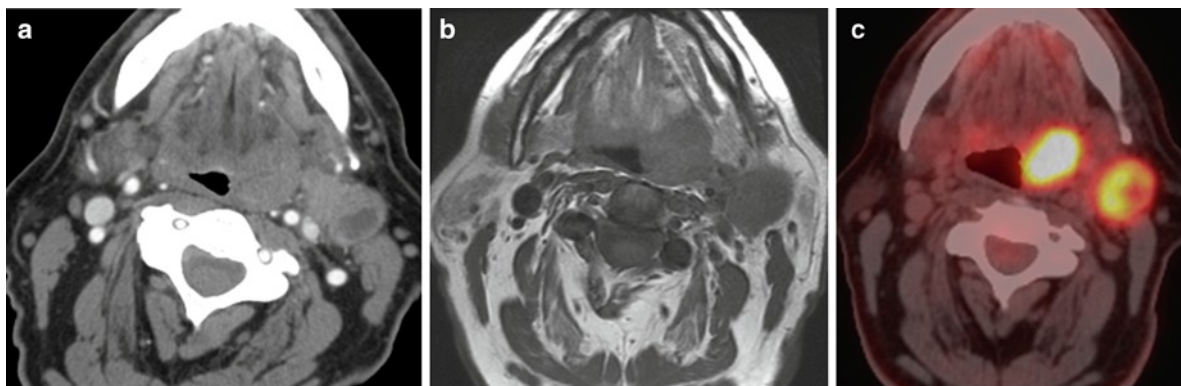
Imaging evaluation of a T2 N2b left base of tongue squamous cell carcinoma by various modalities: (a) CT with iodinated contrast (b) MRI (c) PET/CT
